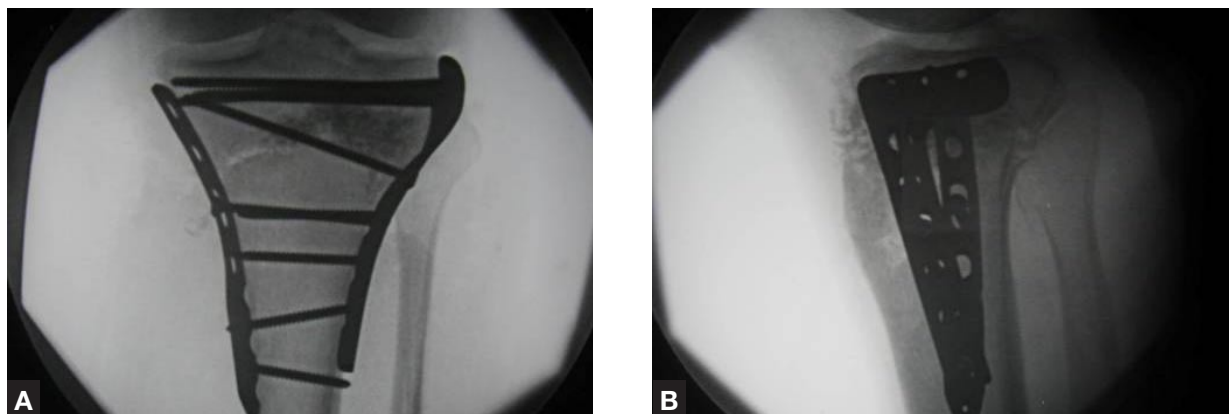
Postoperative anteroposterior (A) and lateral (B) x-rays verify acceptable reduction and implant placement.
